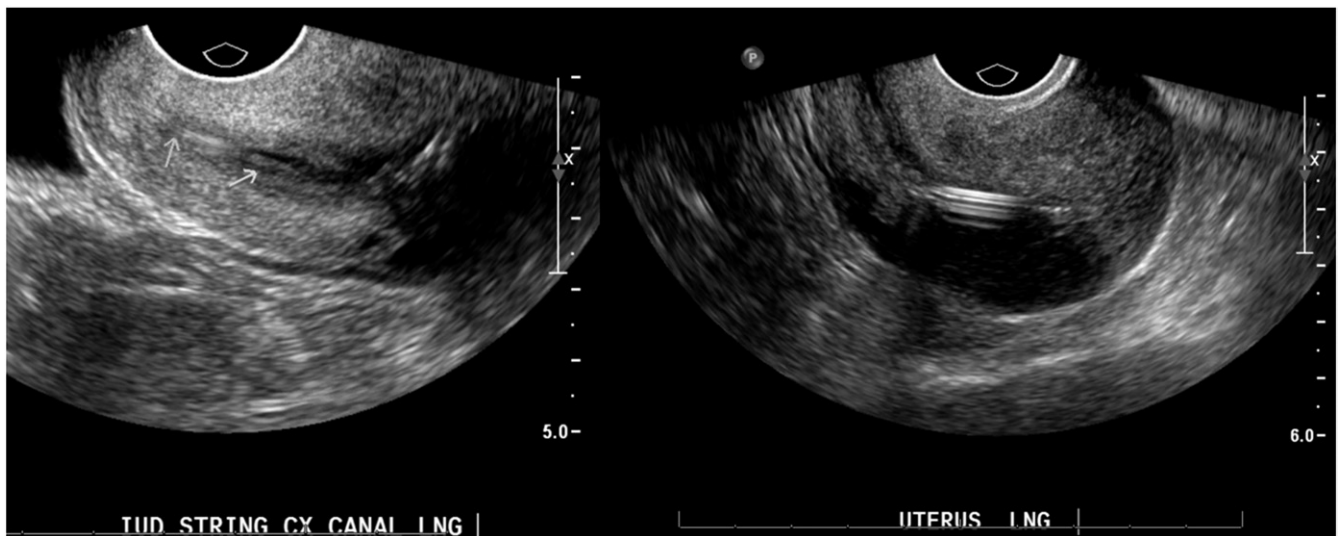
Identification of intrauterine device by intracavitary ultrasound. A hyperechoic linear levonorgestrel intrauterine device can be visualized in the uterine fundus with a light hyperechoic linear signal, representing the intrauterine device strings, passing through the uterine cervix.
